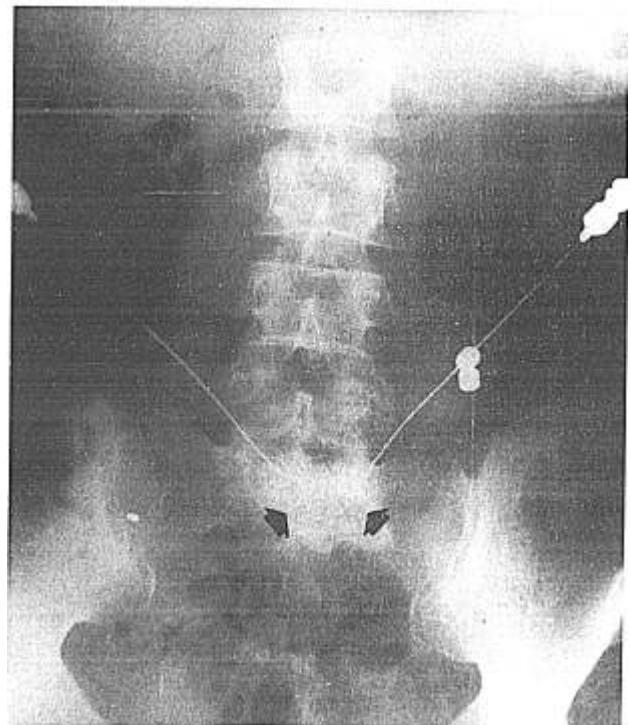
PA radiograph demonstrating correct needle placement. Arrows indicate contrast medium (3-4 ml injected bilaterally) confined to midline.
